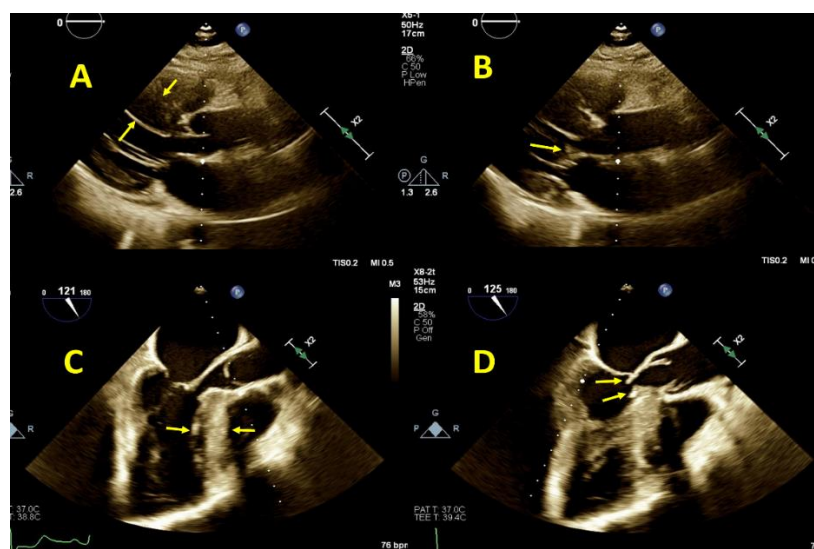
(A) Asymmetric septal hypertrophy (arrows) and (B) a subaortic membrane in the parasternal long-axis view of transthoracic echocardiography (arrow). (C) Asymmetric septal hypertrophy (arrows) and (D) a subaortic membrane (arrows) in the aortic valve long-axis view of transesophageal echocardiography.
